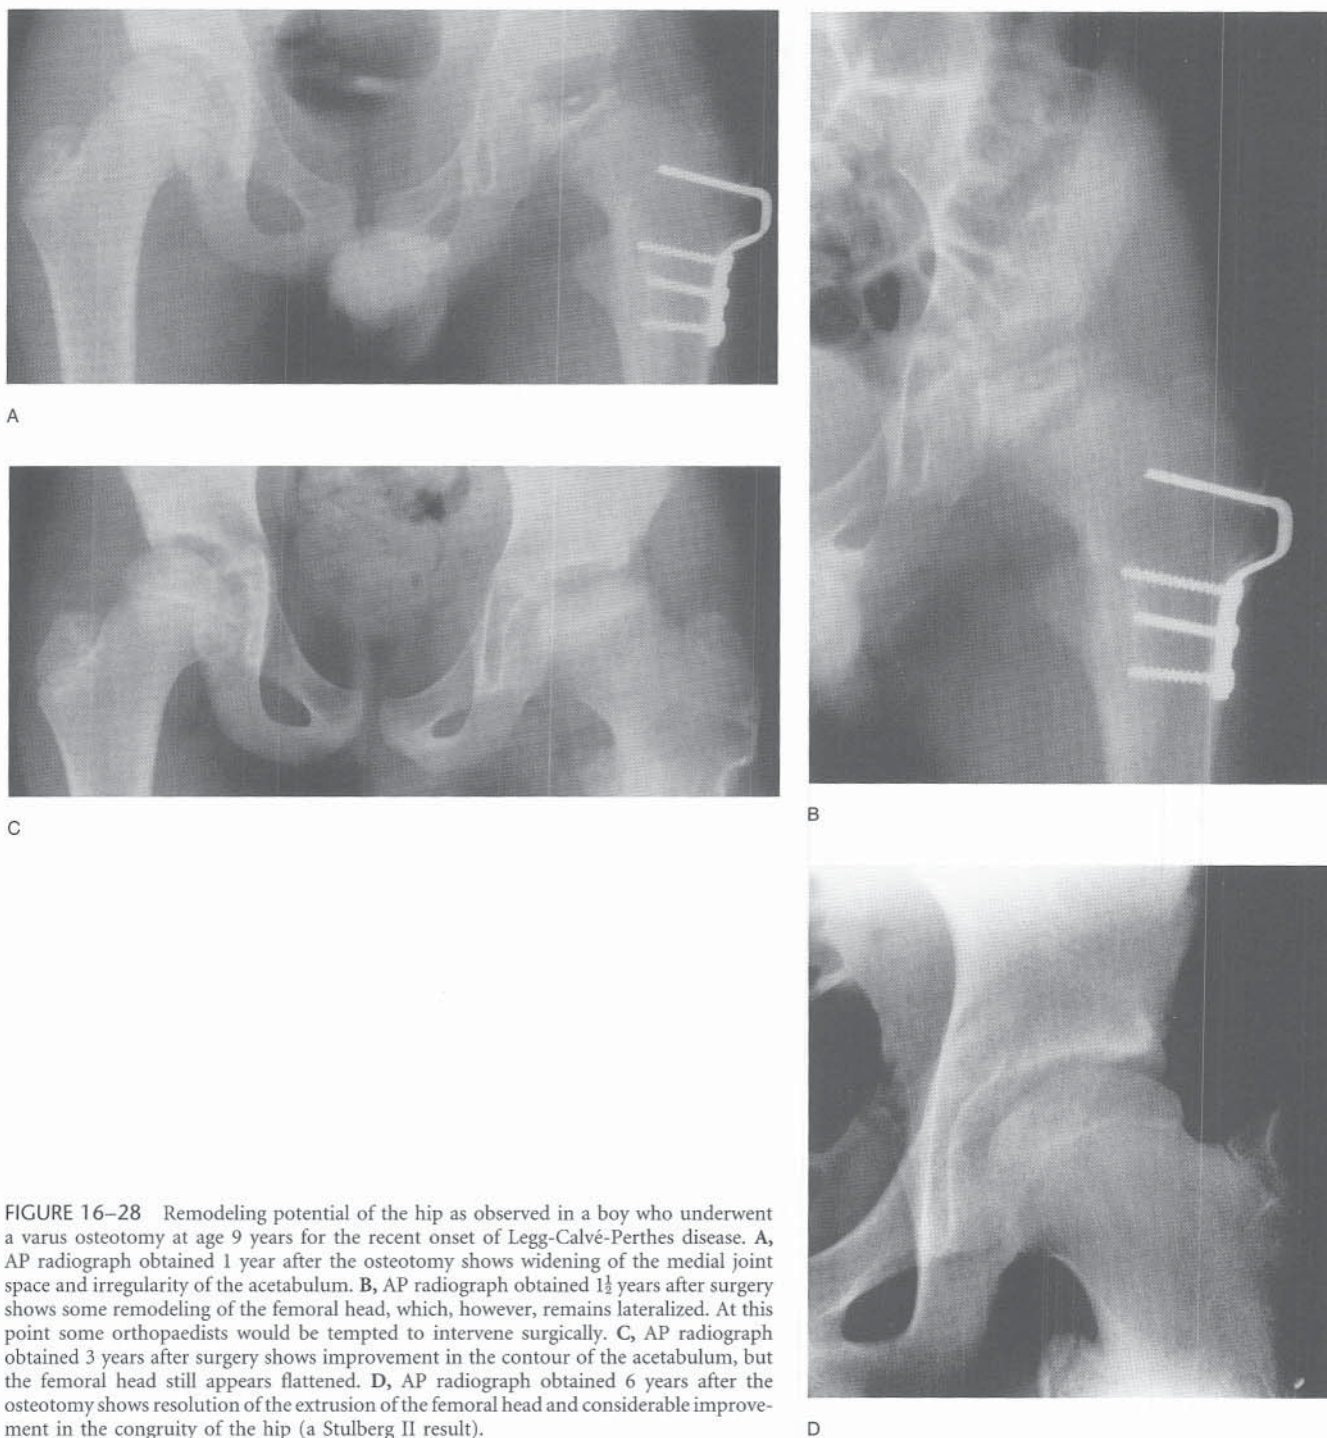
Remodeling potential of the hip as observed in a boy who underwent a varus osteotomy at age 9 years for the recent onset of Legg-Calvé-Perthes disease. A, AP radiograph obtained 1 year after the osteotomy shows widening of the medial joint space and irregularity of the acetabulum. B, AP radiograph obtained 1½ years after surgery shows some remodeling of the femoral head, which, however, remains lateralized. At this point some orthopaedists would be tempted to intervene surgically. C, AP radiograph obtained 3 years after surgery shows improvement in the contour of the acetabulum, but the femoral head still appears flattened. D, AP radiograph obtained 6 years after the osteotomy shows resolution of the extrusion of the femoral head and considerable improvement in the congruity of the hip (a Stulberg II result).
